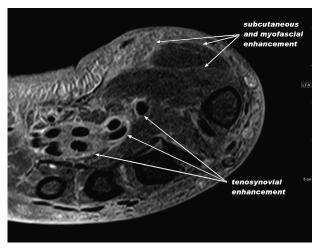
Axial T2 MRI of the right hand demonstrating diffuse subcutaneous and deep fascial edema and enhancement. Mild diffuse tenosynovial enhancement involving both the long flexor and the extensor tendon compartments.
